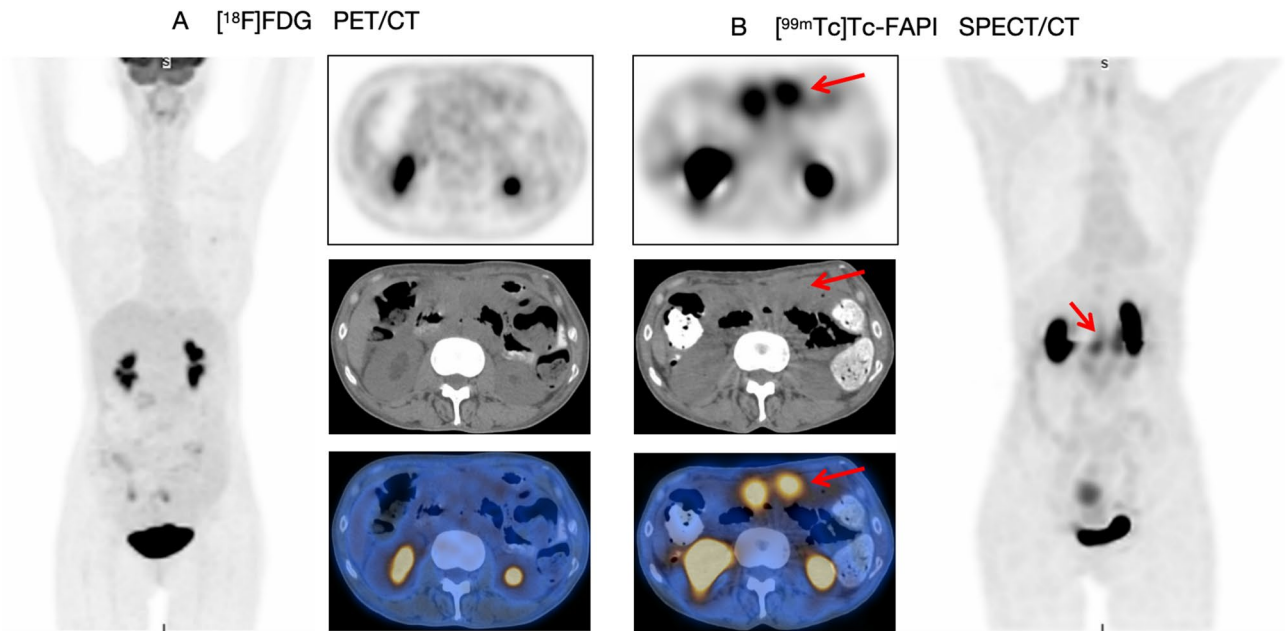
An 63-year-old woman (patient number 27), confirmed a poorly cohesive gastric carcinoma by surgery, underwent $[^{18}\text{F}]\text{FDG}$ PET/CT and $[^{99\text{mTc}}]\text{Tc-FAPI}$ SPECT/CT scan to detect recurrence. $[^{99\text{mTc}}]\text{Tc-FAPI}$ SPECT/CT showed higher tracer uptake than $[^{18}\text{F}]\text{FDG}$ PET/CT (red arrow) for peritoneal carcinomatosis. Then, the ultrasound-guided abdominal puncture was performed, and the tumor cells were found in ascites, which confirmed the true-positive of $[^{99\text{mTc}}]\text{Tc-FAPI}$ SPECT/CT.
